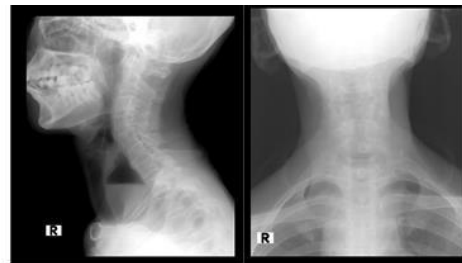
Soft tissue X-ray examination of the neck shows inhomogeneous opacity in the right paratracheal.
